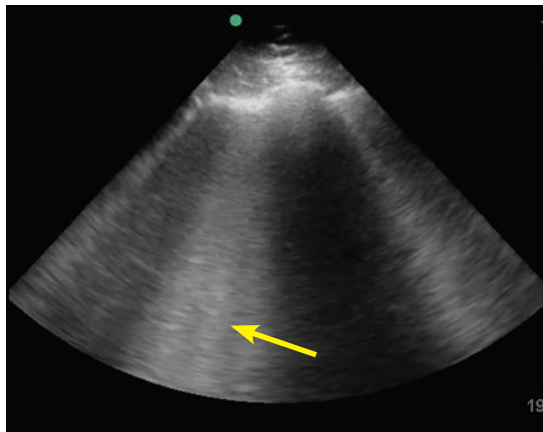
B lines. The B-line pattern occurs in the setting of interstitial thickening by any cause, including cardiogenic pulmonary edema, noncardiogenic pulmonary edema, interstitial fibrosis, and interstitial pneumonia/pneumonitis. It is analogous to ground-glass opacity on computed tomography. It is demonstrated by vertical lines resembling the tail of a comet and extending to the bottom of the screen. In this image, confluent B lines (arrow) indicate significant interstitial involvement.
